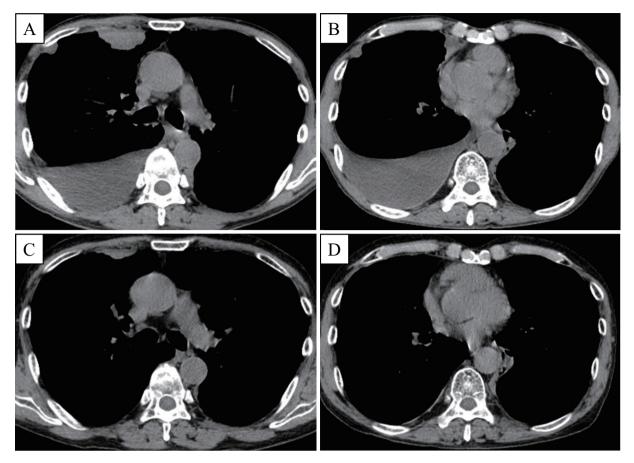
Changes in radiological findings. A, B: Chest CT in November 2017 with a diagnosis of malignant pleural mesothelioma. CT reveals multiple tumor shadows at the pleura and interlobar pleura on the right side along with right pleural effusion. C, D: Chest CT in November 2018. The pleural effusion had disappeared, and the pleural mass lesion showed regression.
